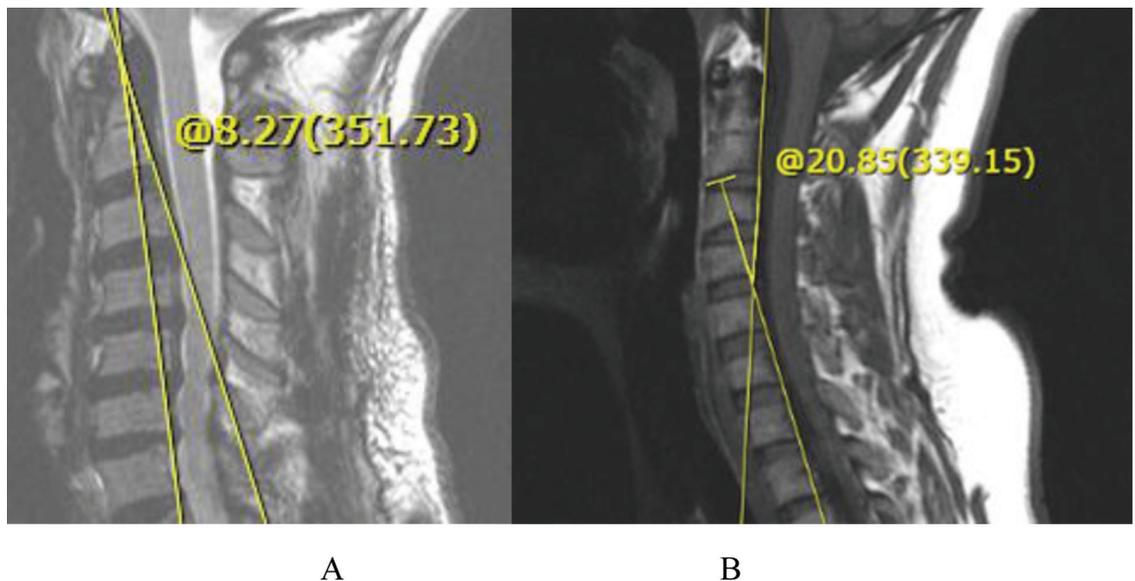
Cervical MRI demonstrated a kyphotic deformity (A) with posterior tangent angle -8.27° , and hypo-lordotic with posterior tangent angle 20.85° (B)
